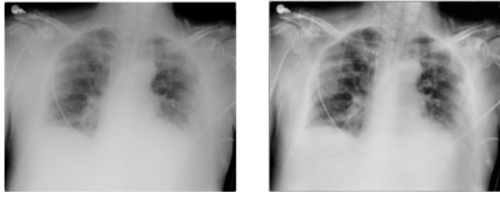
Covid X-ray before and after applying CLAHE
